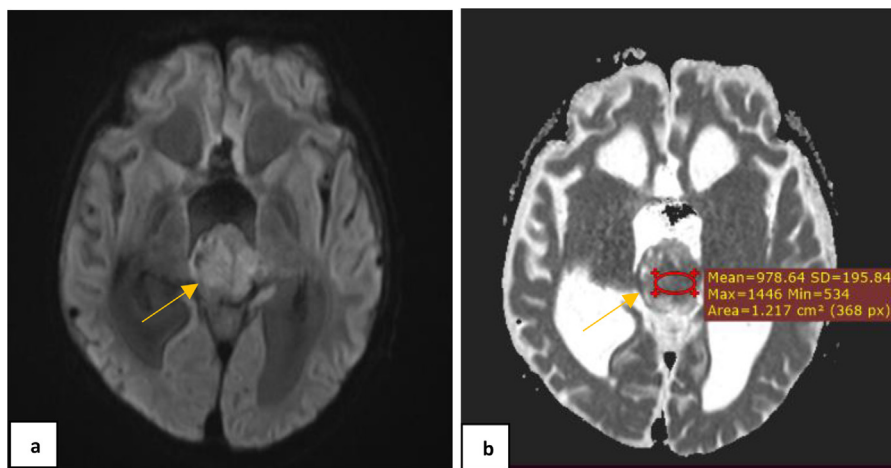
The tumor (yellow arrow) showed restricted diffusion in DWI (A)-ADC (B) with ROI taken in the solid part of the mass in ADC map revealed mean ADC value $978 \times 10^{-6} \text{ mm}^2/\text{s}$.
